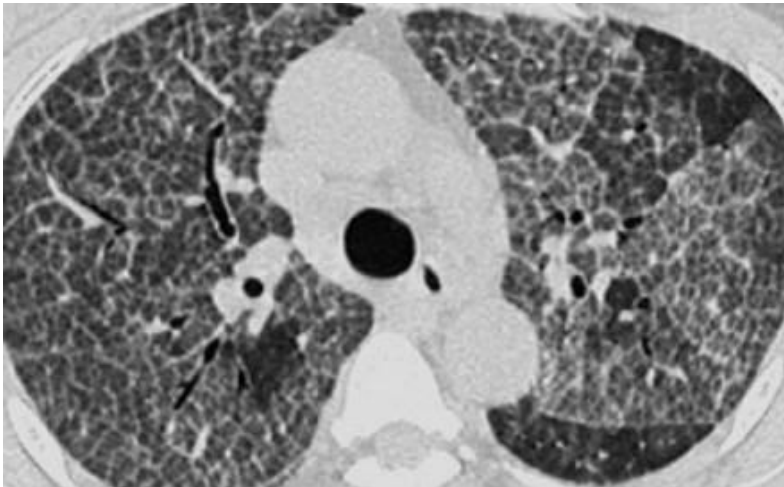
Pneumocystis pneumonia in a 37-year-old man with acquired immunodeficiency syndrome (AIDS) (cluster of differentiation 4+ [CD4+] count, 75 cells/ μ L). (A, B) Lung window image of computed tomography scan (2.5-mm-section thickness) obtained at levels of carina and lung base, respectively, demonstrate diffuse ground-glass opacity with geographic pattern (arrows). Also note smooth interlobular septal thickening showing crazy-paving appearance (arrowheads).
